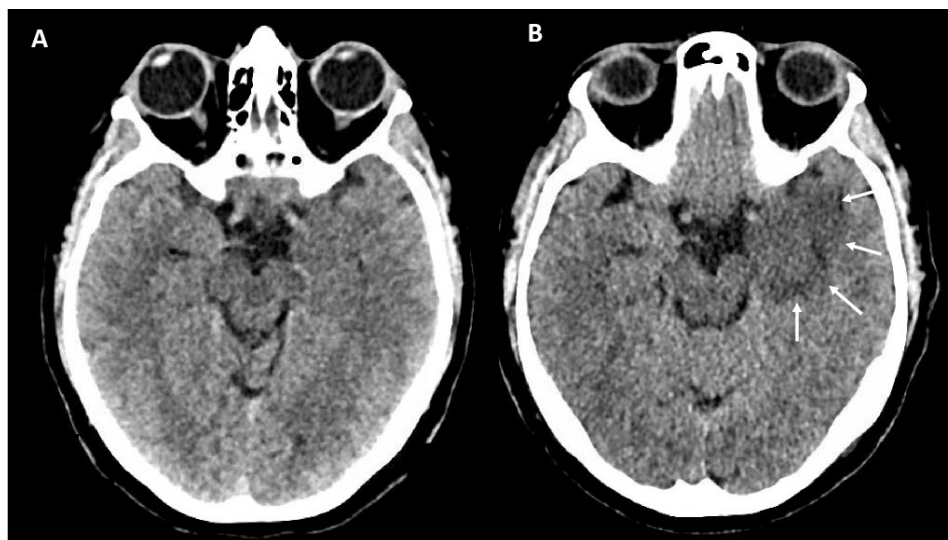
Timing of mesio-temporal edema onset: Comparison between CT on day of epileptic seizure (left) vs. 3 days post-seizure (right).
